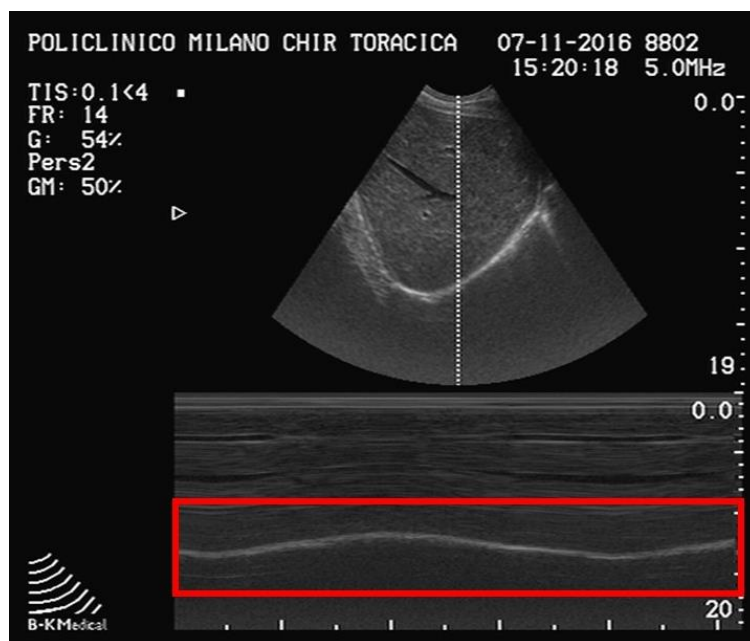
Ultrasonography of the diaphragm in M mode, in the red rectangle is highlighted the diaphragmatic motion during the breaths.
